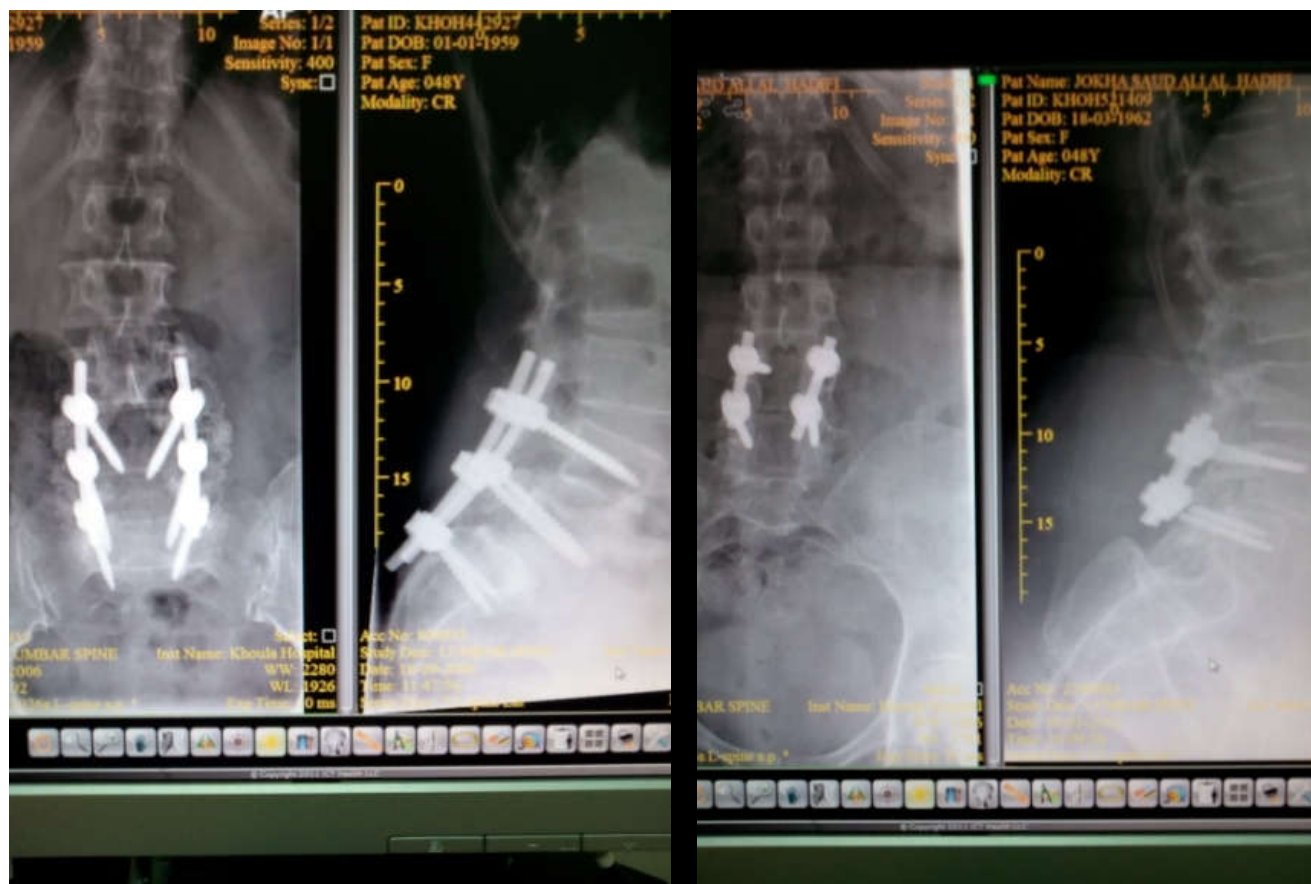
Use of Xray alone in our patient s with pre op x ray and MRI images
